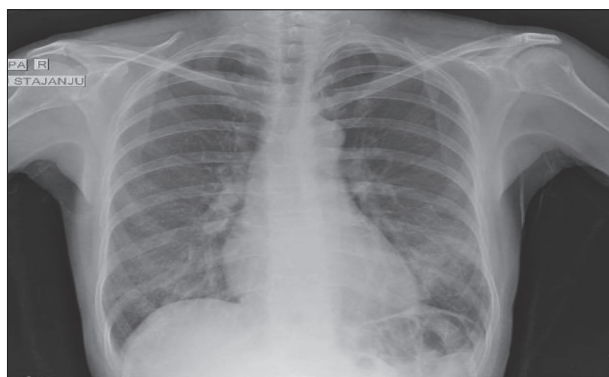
Chest X-ray showing signs of a bilateral pneumonia
